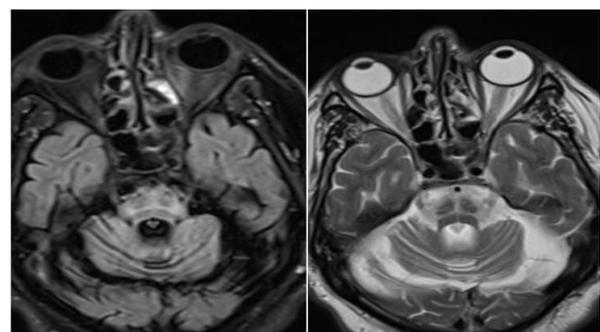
The MRI scan of one patient with MSA-C. The hot cross bun sign of the pon and cerebellar atrophy is very common on course of the MSA.
